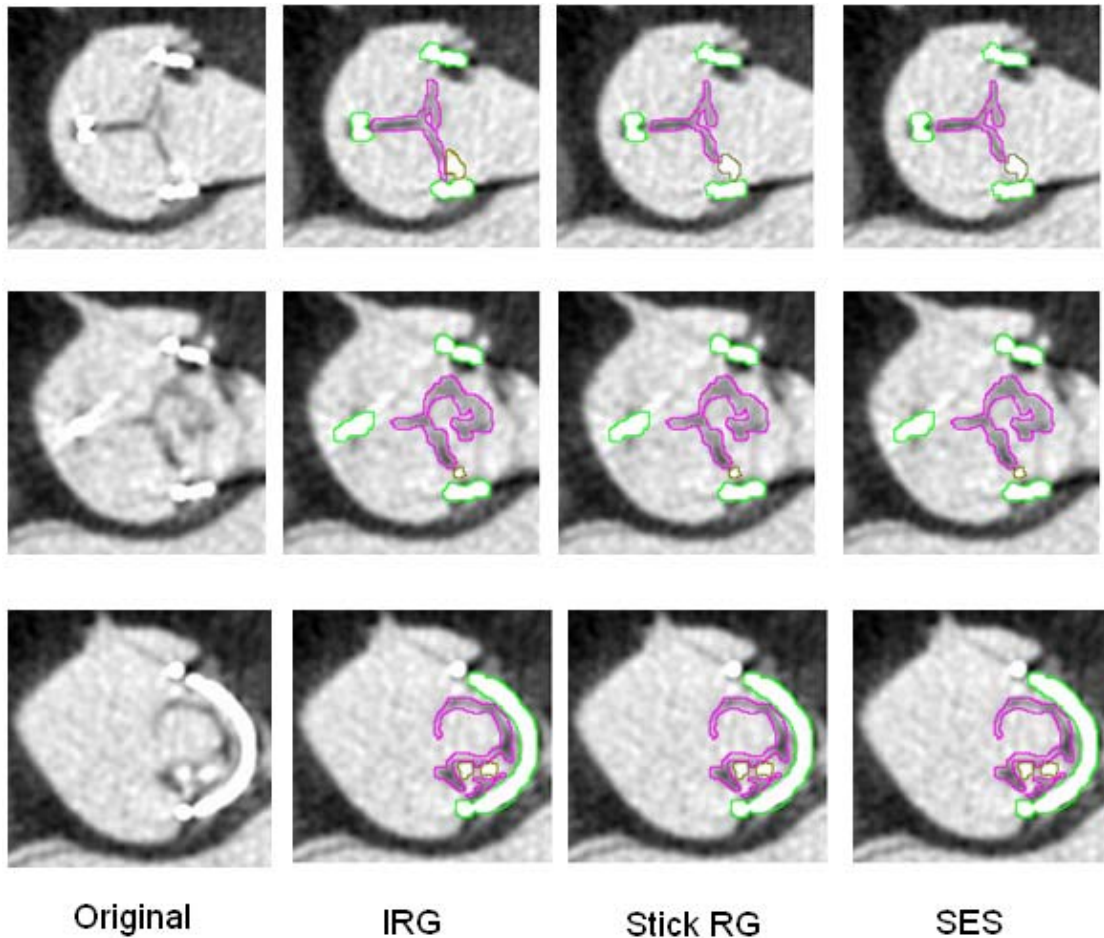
Examples of segmented CT-Slices obtained in case 1 - HER: metallic stent, calcifications and leaflets are indicated by green, brown and purple border respectively.
